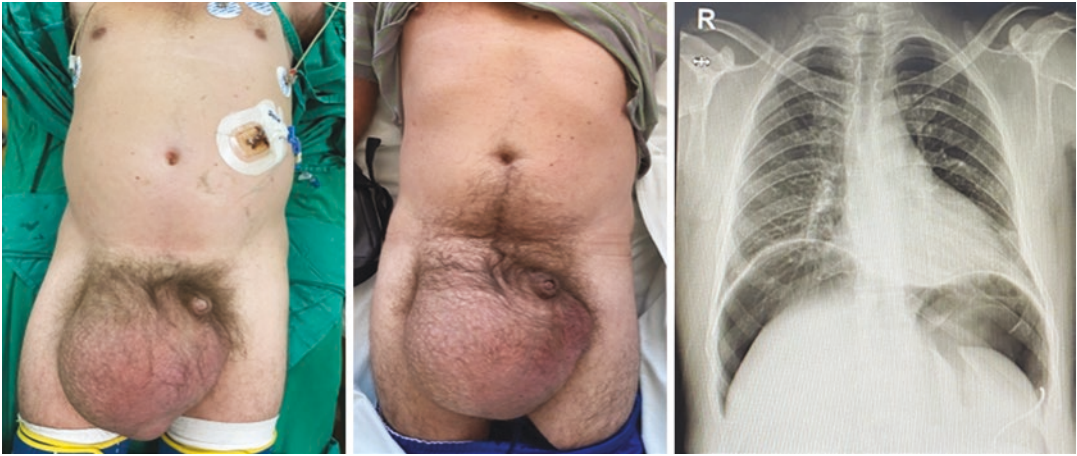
Inguinoscrotal hernia with loss of domain, Tanaka index of 30%. Placement of PPP catheter in Palmer's point with Veress needle. Radiography with pneumoperitoneum
